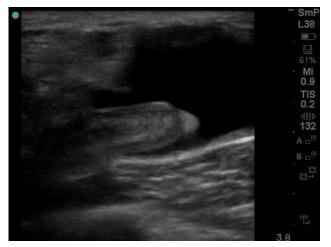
Long axis view ultrasound of an inguinal mass.
